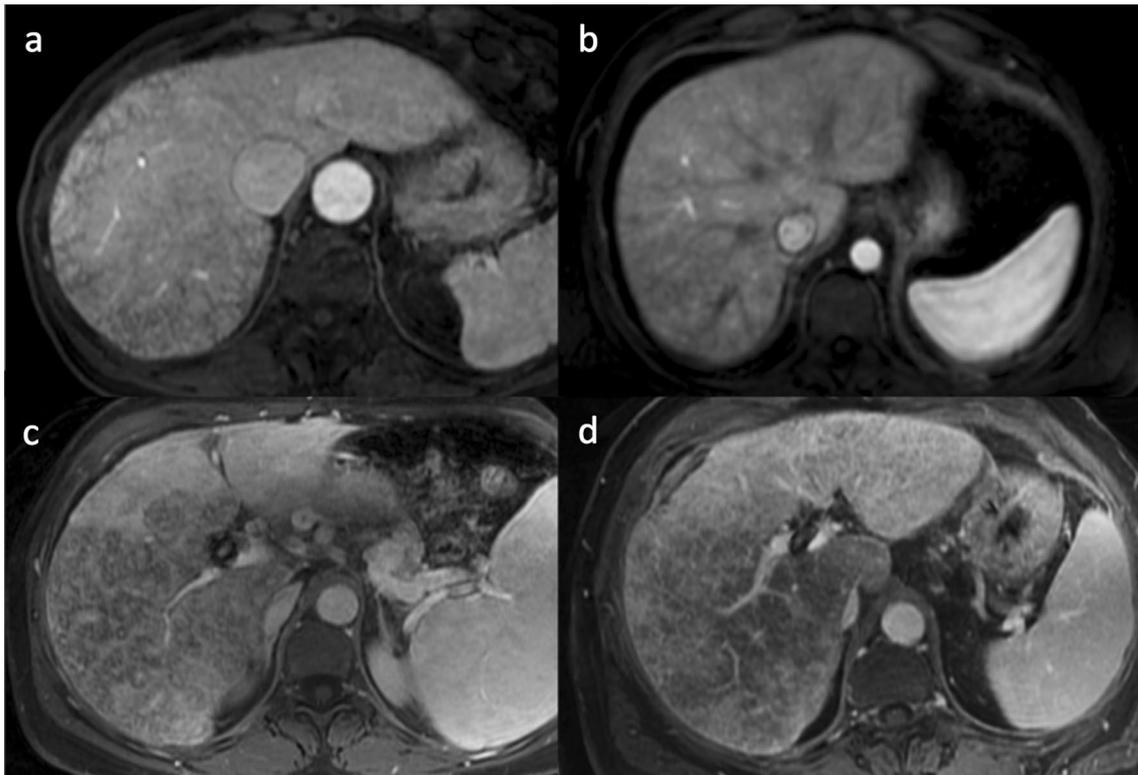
Axial arterial and portal phase MR images showing different causes of mosaic pattern: heart failure (a), constrictive pericarditis (b), Budd-Chiari Syndrome (c), and drug abuse in patient with alcohol-related cirrhosis (d)
